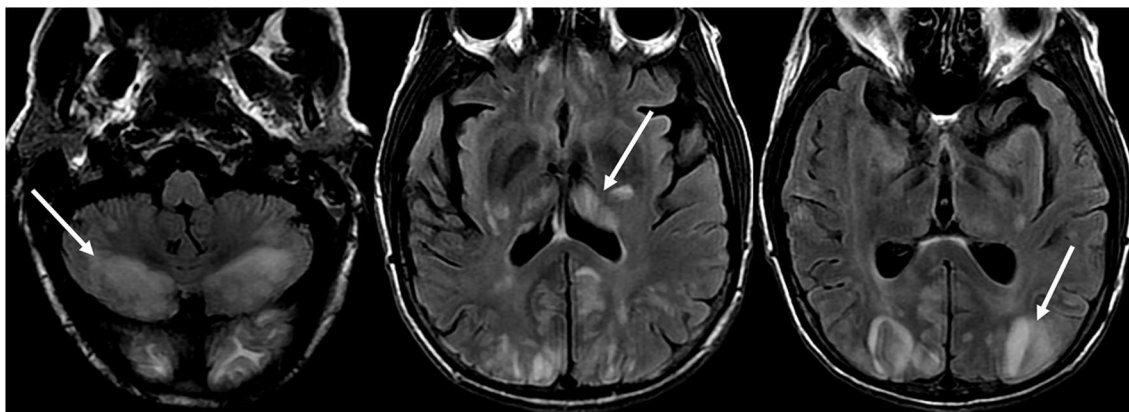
Patient with liver transplantation 6 weeks earlier. The patient was started on Tacrolimus after liver transplantation. T2-FLAIR images of the brain demonstrate signal abnormality in the occipital lobes. There is also extensive signal abnormality seen in the bilateral cerebellar hemispheres and within the thalami. These findings quickly resolved after stopping the Tacrolimus.
